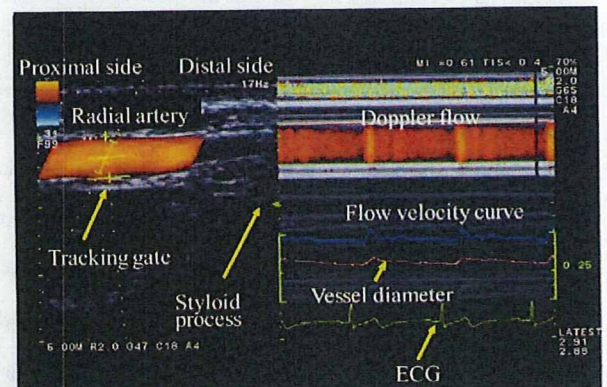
Vessel image and position of the tracking gate (left). Changes of radial artery diameter, Doppler flow, and flow velocity (right) determined with an automated edge detection device and computer analysis software.
